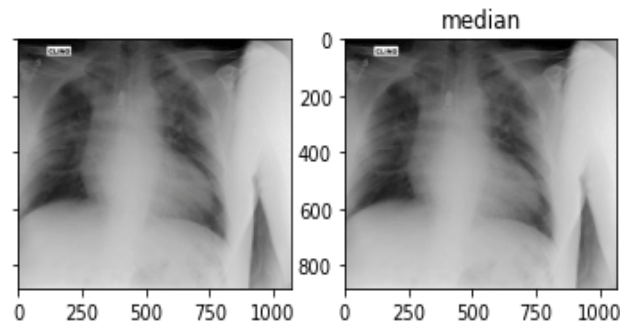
(b). Outputs of second X-Ray image before and after filtering it using Median Filter
